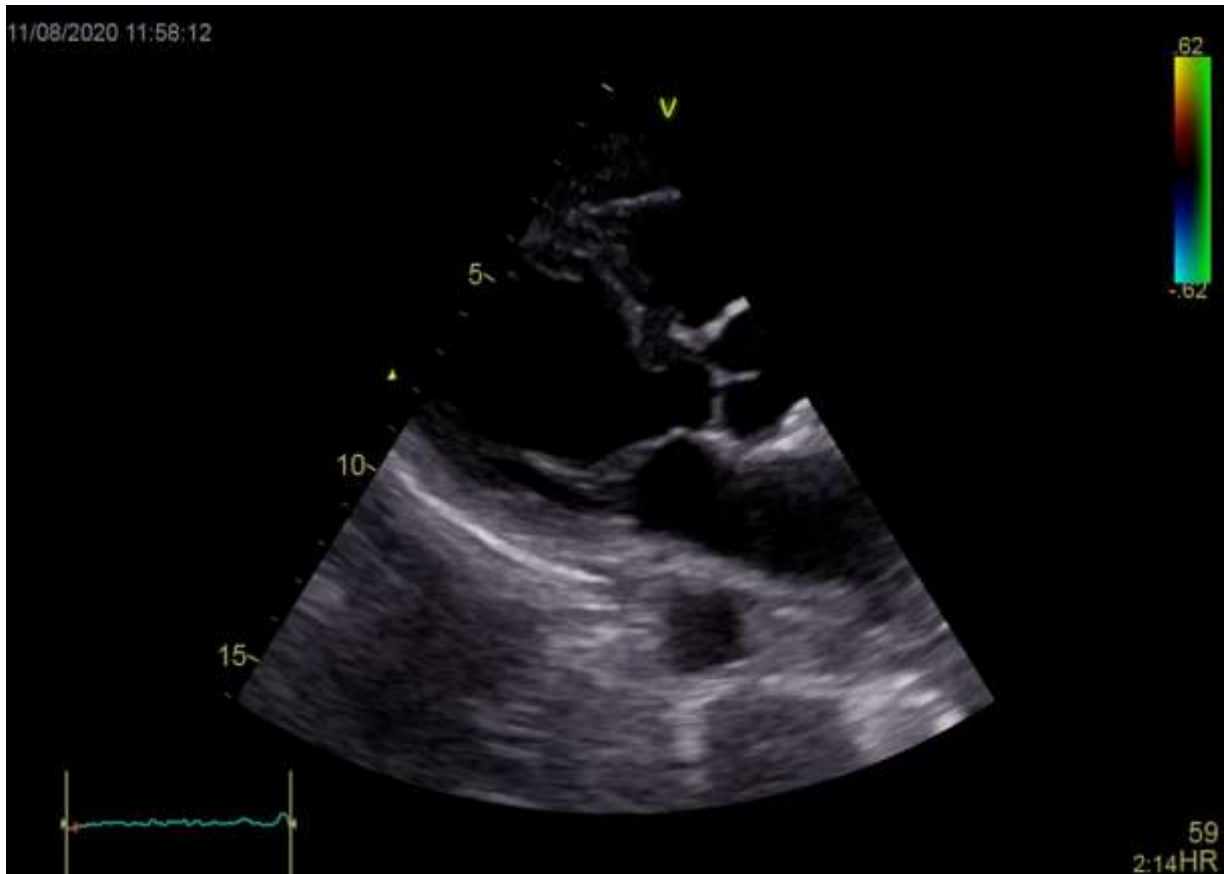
Trans-thoracic echocardiography, upon presentation, in the four-chamber view showing mid to apical infero-septal and antero-lateral akinesia with apical ballooning.
